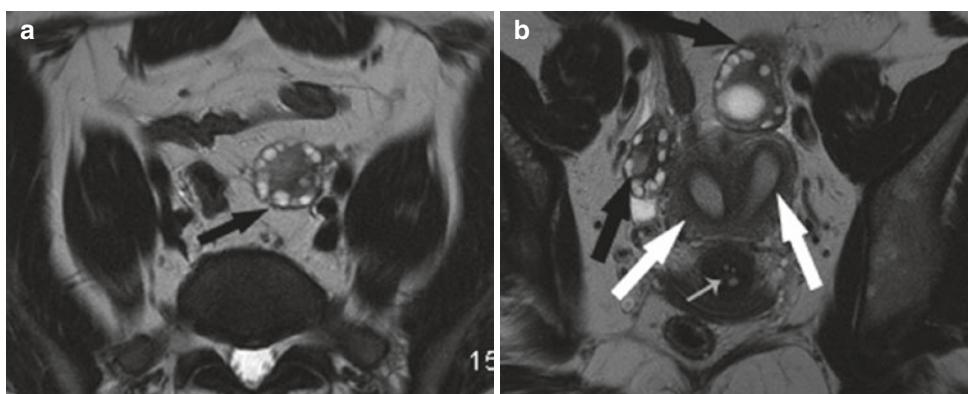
(a) Axial T2-weighted MR image in a 32-year-old woman being assessed for abnormal uterine shape on ultrasound. The left ovary has numerous peripheral follicles (black arrow). (b) Coronal T2-weighted MR image
